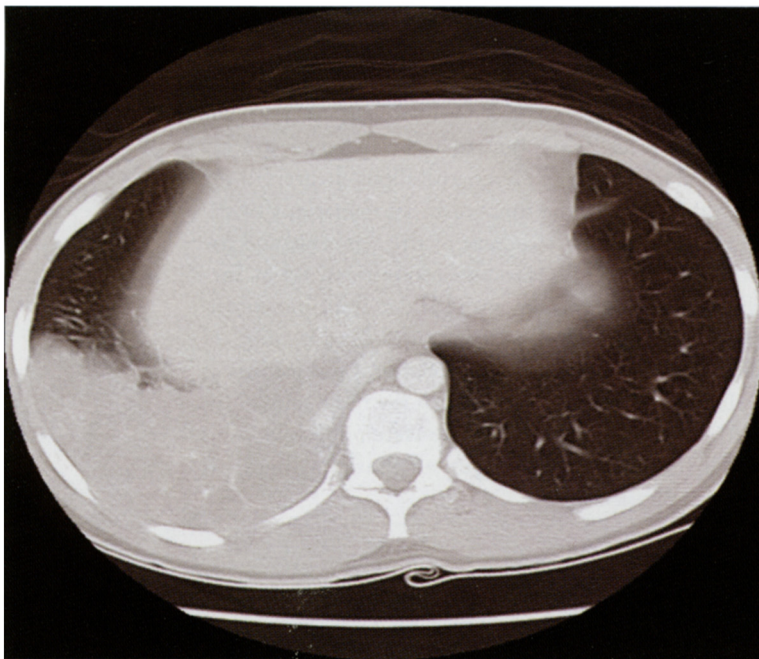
Contrast CT scan
